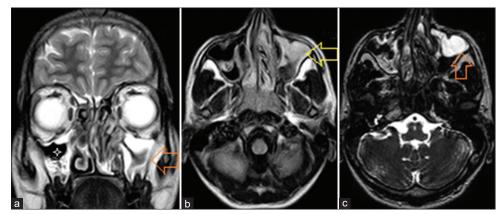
Magnetic resonance imaging of peripheral nervous system. (a) T2WI coronal section shows hyperintensity in the left maxillary sinus extending through the left osteomeatal complex (red arrow) with mucosal hypertrophy in aerated right maxillary sinus (white star). (b) Fluid-attenuated recovery axial section highlights the hyperintense fungal mass (yellow arrow). (c) T2WI drive shows the abnormal hyperintense fungal areas
